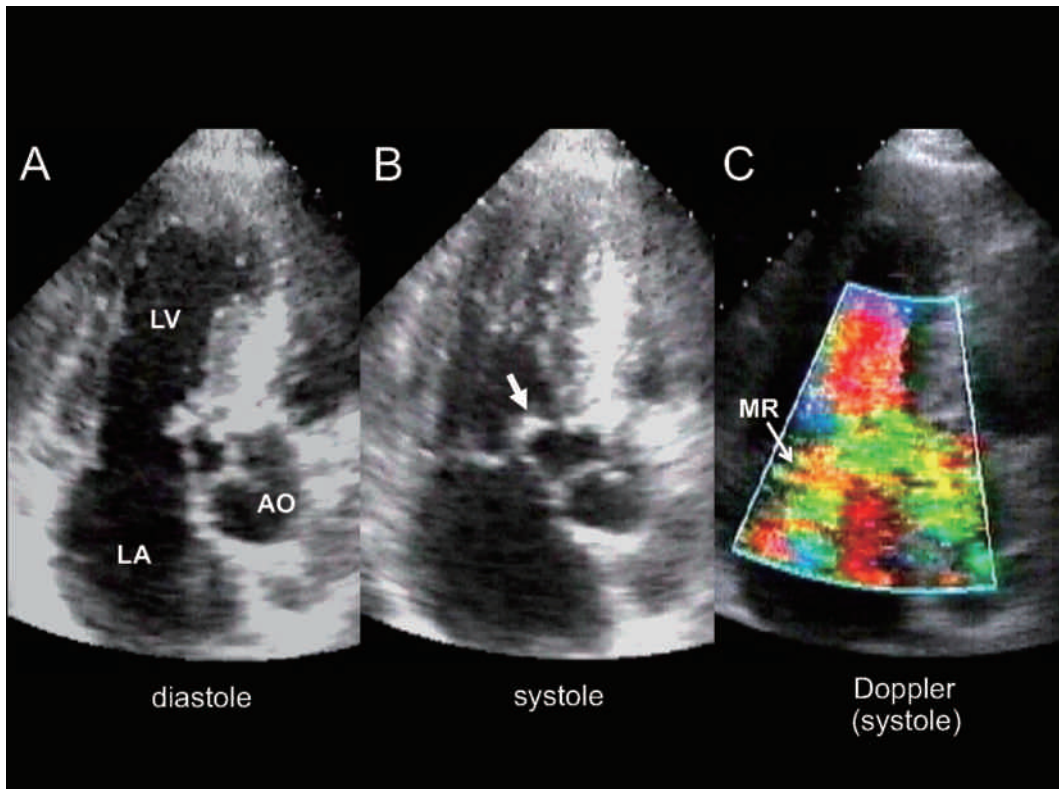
Echocardiographic images in transthoracic apical long axis view at the first presentation. A, Two-dimensional image on diastole. Asymmetrical left ventricular hypertrophy was seen. B, Two-dimensional image on systole. Systolic anterior movement of the anterior mitral leaflet (arrow) caused outflow obstruction. C, Color Doppler flow image on systole. Mitral regurgitation jet was oriented posteriorly in the left atrium. AO=aorta; LA=left atrium; LV=left ventricle; MR=mitral regurgitation.
